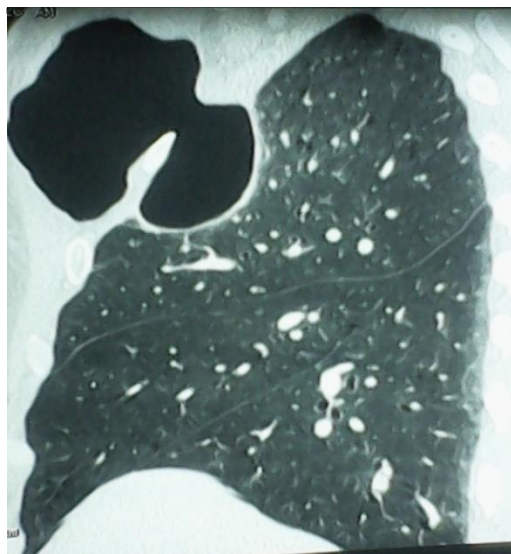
Pneumatocele as showed by the para-sagittal chest CT
